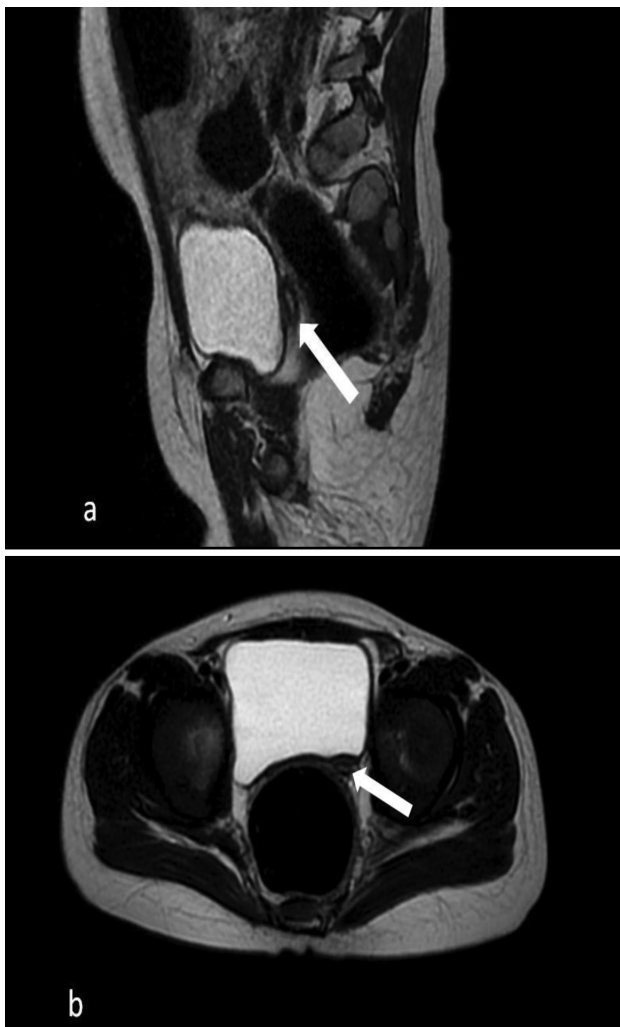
Rudimentary uterus is shown on the sagittal T2 (a) and axial (b) T2-weighted magnetic resonance images
